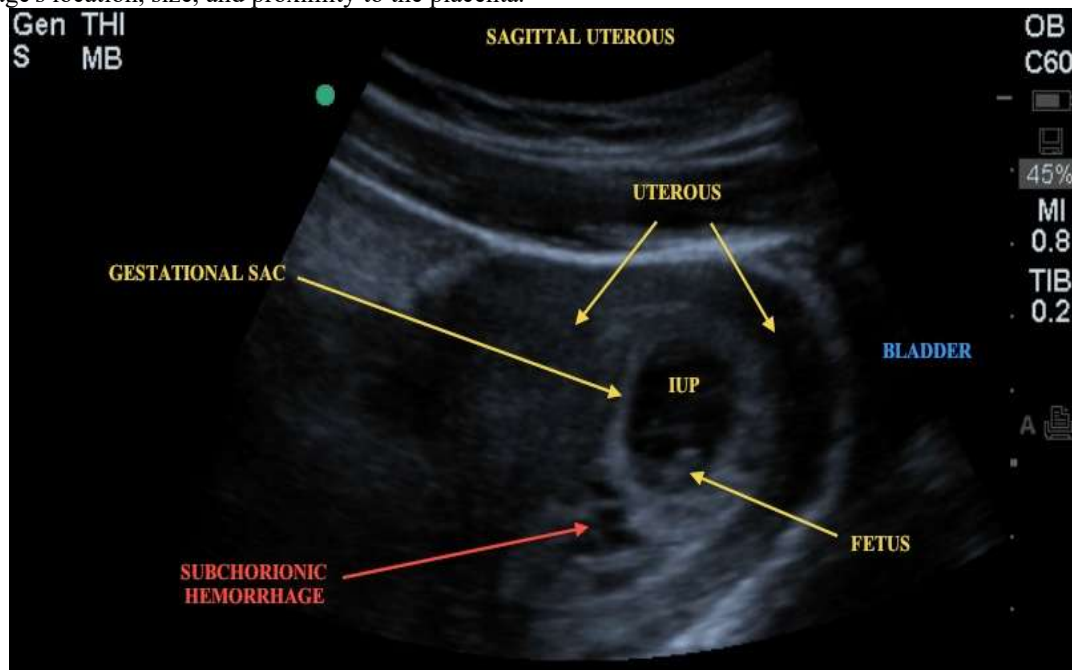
Transvaginal Ultrasound Showing Subchorionic Haemorrhage.
